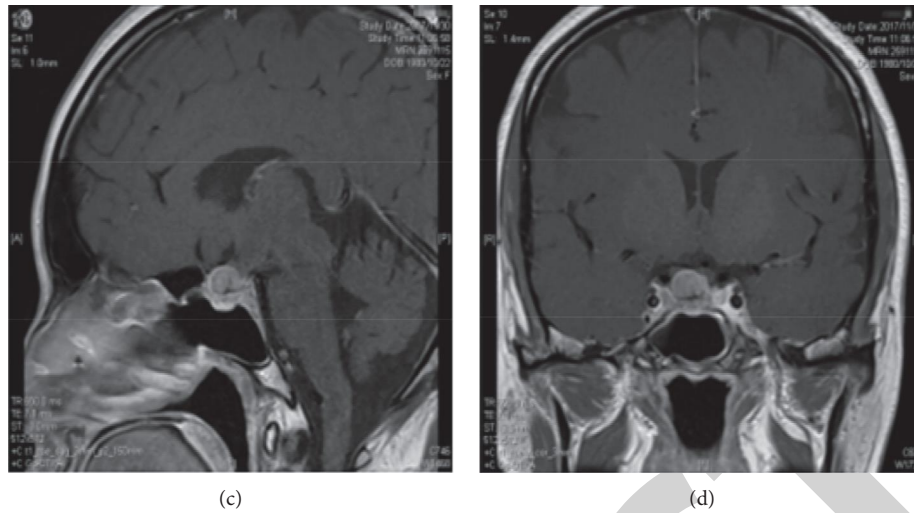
Pituitary adenomas in different periods after treatment: (a) 3 days after surgery, pituitary MRI sagittal; (b) 3 days after surgery, pituitary MRI sagittal; (c) 3 months postoperative pituitary MRI sagittal position; and (d) pituitary MRI sagittal position 3 months after the operation.
